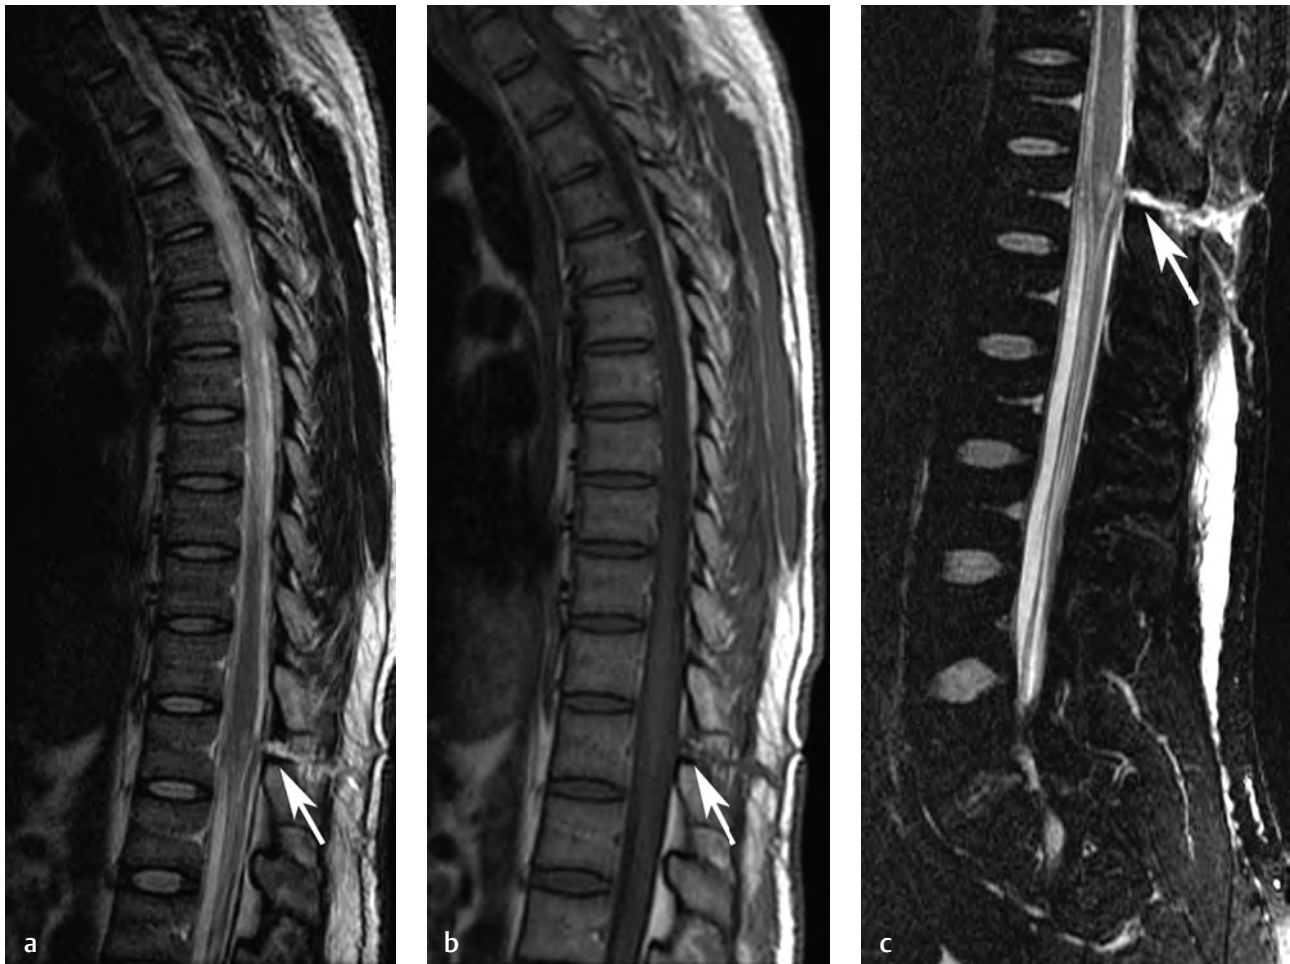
Cord injury from a stab injury to the conus medullaris. (a) A sagittal T2-weighted image of the thoracic spine shows a linear track (*arrow*) from the skin to the conus medullaris with an associated region of increased signal within the conus medullaris, compatible with edema. (b) A sagittal T1-weighted image of the thoracic spine also shows the track (*arrow*) but does not show the edema within the conus medullaris. (c) A sagittal STIR image of the lumbar spine accentuates the edema along the track (*arrow*) and also that within the conus medullaris.[†]
